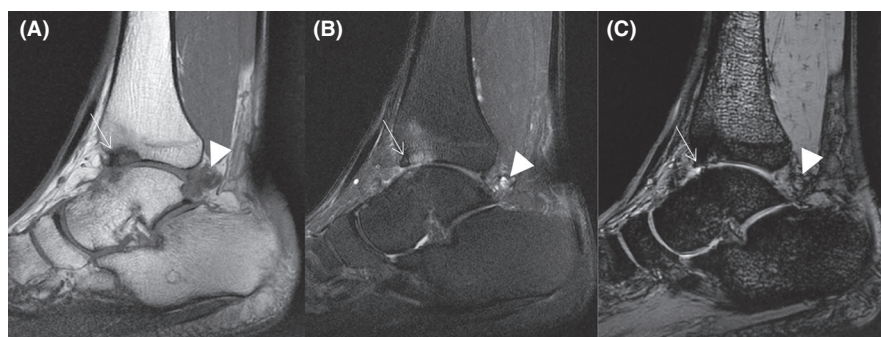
MRI spin echo T1 (A), spin echo fat-suppressed-T2 (B) and gradient-echo T2 (C)-weighted images acquired in the sagittal plane on the ankle in a patient with haemophilia. Presence of osteochondral changes with focal cartilage loss and subchondral cyst predominant at the anterior aspect of the tibia (arrows). The posterior articular recess shows limited synovial hypertrophy and haemosiderin deposit (arrow heads)
